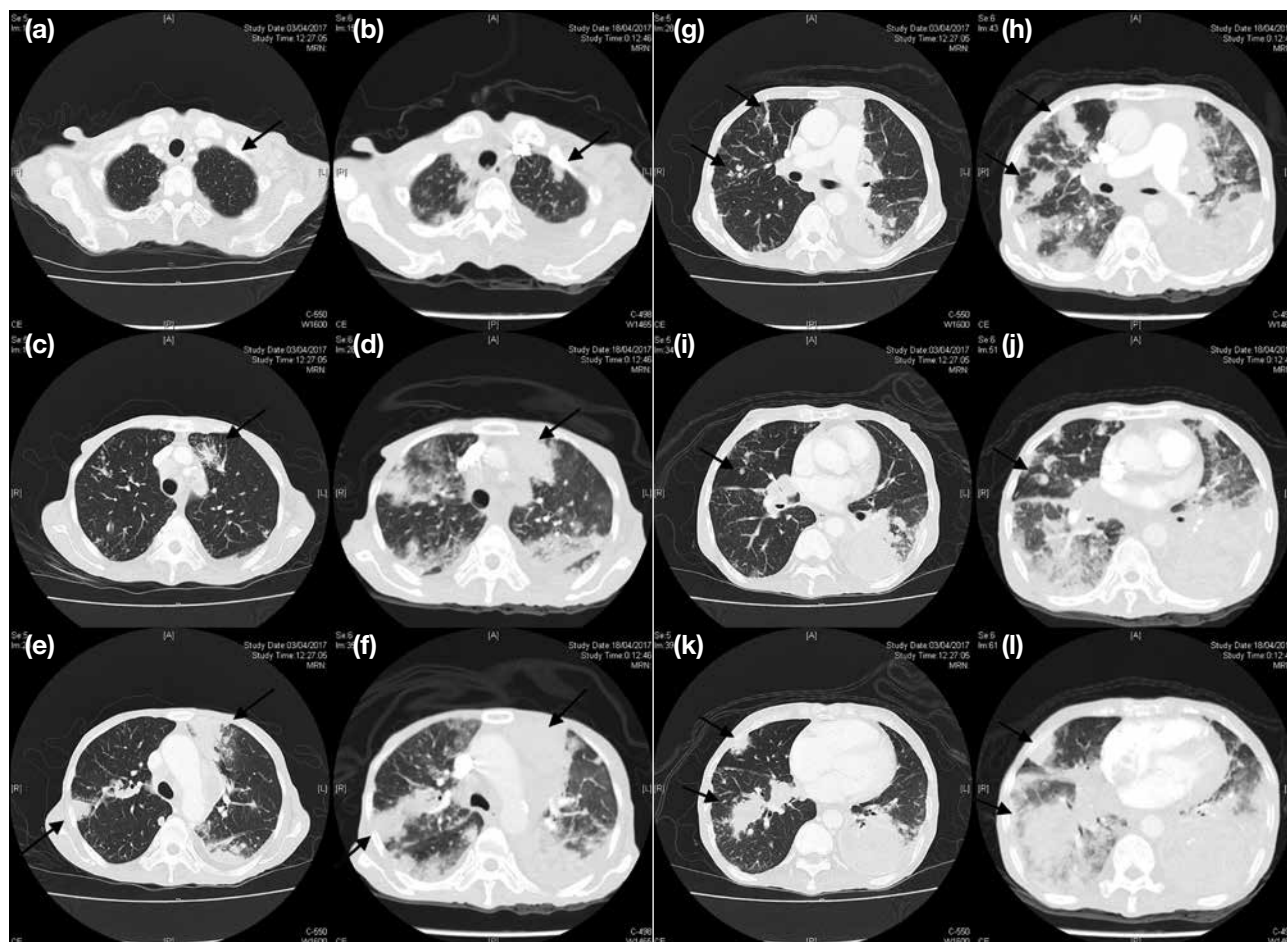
The same 64-year-old woman with clear cell renal cell carcinoma. Arrows in contrast computed tomography images show (a, b) interval development of new lung metastasis, (c, d) interval increase in size of patchy consolidation in sites of metastasis; (e, f) interval increase in size of lung metastasis and development of new consolidative changes; and (g to l) interval increase in size of lung metastasis.
